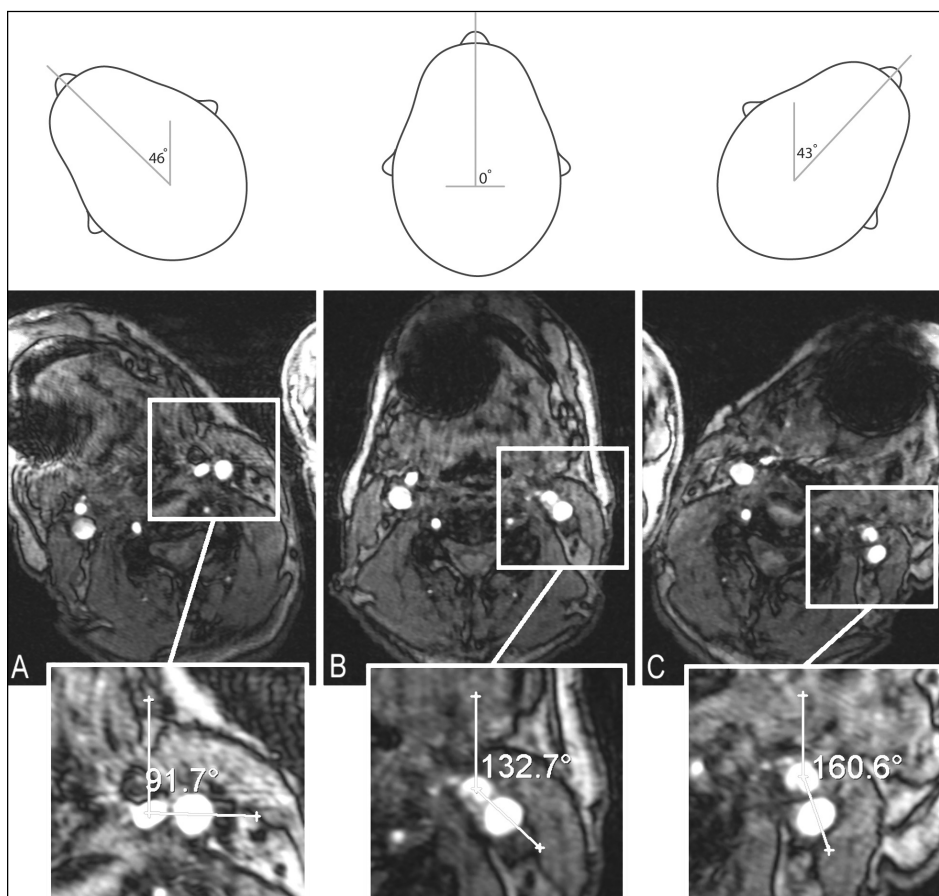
MR images of a 69-year-old man following stent placement in the left ICA. Transverse sections at the level of the bifurcation in different head positions, turned right (A), neutral (B), and turned Left (C), were used to measure torsion shear of the carotid artery. Common carotid artery torsion shear equals the rotation of the bifurcation; ICA torsion shear equals the head rotation minus rotation of the bifurcation.
